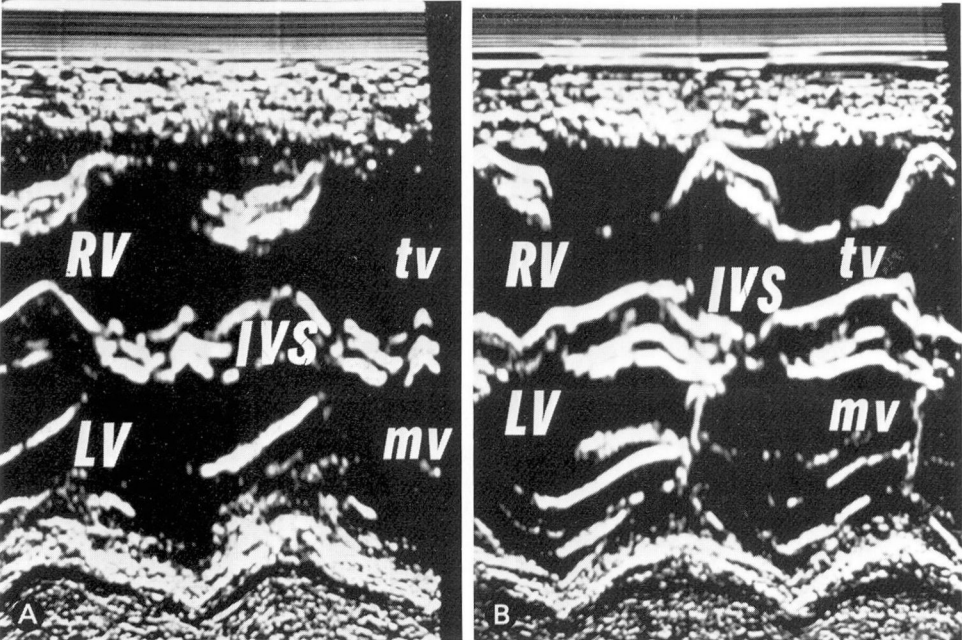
M-mode echocardiogram in patient 3 at the level of the left ventricular posterior wall demonstrating a dilated right ventricle with paradoxical septal motion in that the septum moves parallel to the left ventricular wall instead of toward the wall during systole. RV = right ventricle, LV = left ventricle, tv = tricuspid valve, mv = mitral valve, IVS = interventricular septum. B. M-mode echocardiogram in patient 5 demonstrating paradoxical septal motion as described in Figure 1A. The right ventricle is again noted to be dilated.
